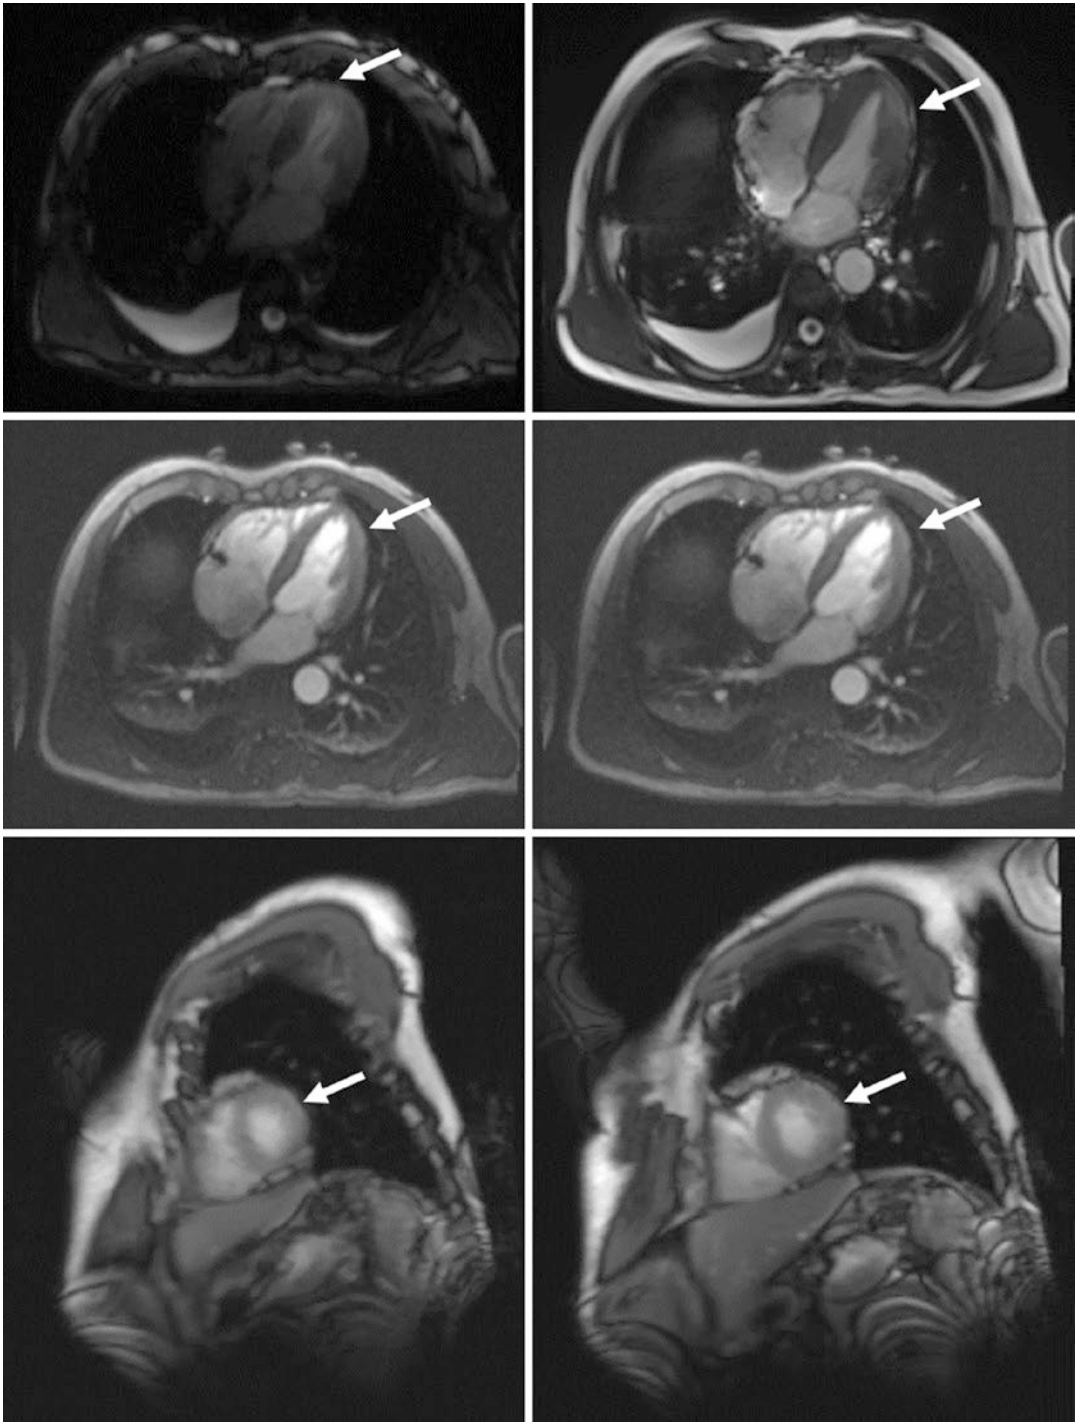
Magnetic resonance imaging-perfusion imaging-multi-directional delayed enhancement on the eighth day of hospital stay. Diagnostic hints: basal segment lateral wall, inferior wall and middle segment to apical segment myocardial edema, and apical segment
